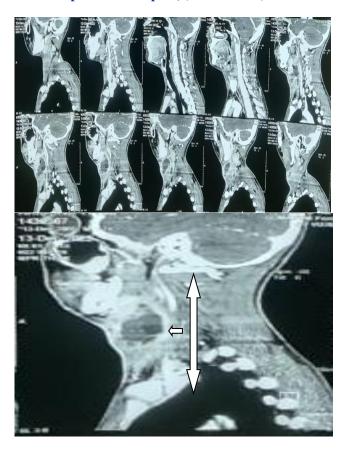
CT scan Sagittal view-Collection in the left para-carotid space, (White arrow-double ended).
